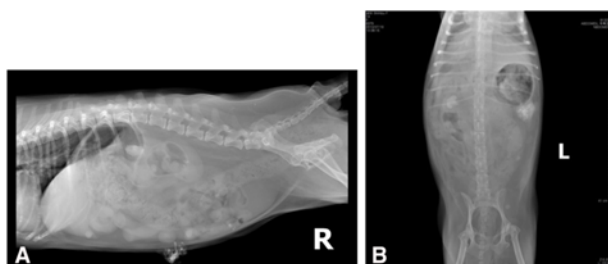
Abdominal radiograph showing the (A) ventrodorsal, and (B) lateral views. Gastric gas distention was observed.
